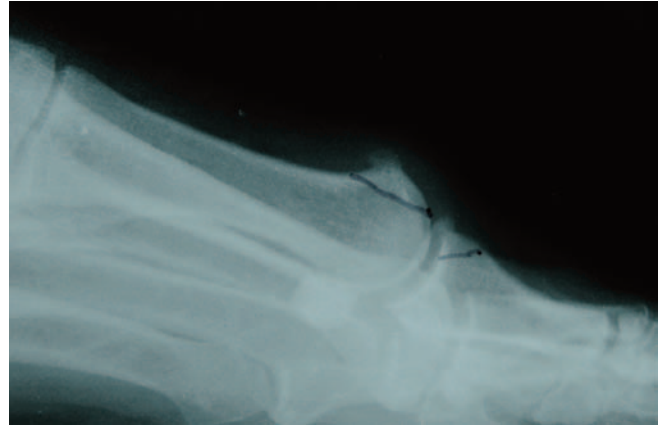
Case Study 3. Preoperative lateral radiograph.
